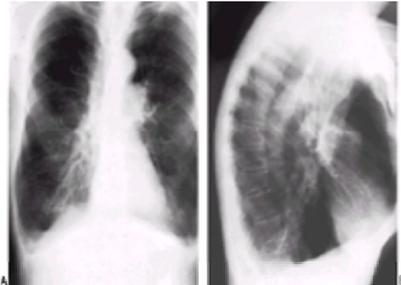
Chest roentgenogram from a patient with severe COPD. In the posteroanterior projection (*left*), the lungs appear hyperinflated with attenuation of the peripheral lung markings. The lateral projection (*right*) shows loss of the normal contour of the hemidiaphragms and an increase in the retrosternal clear space.
